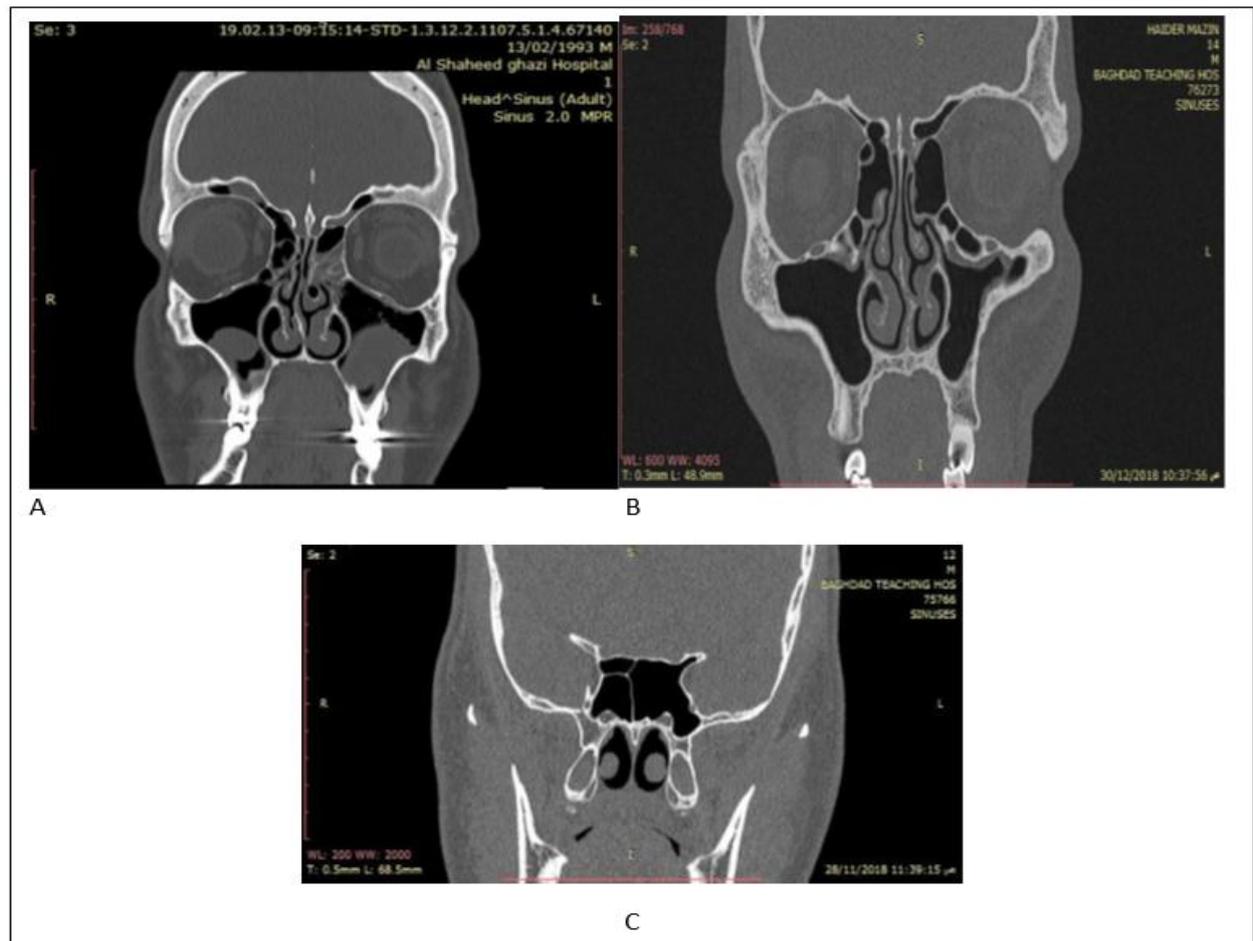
CT scan shows (A) right sided nasal septal deviation and left sided concha bullosa, (B) bilateral haller cells and left sided septal nasal deviation, (C) right sided onodi cell.
